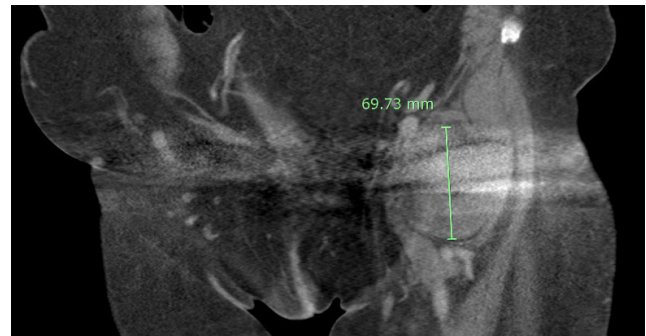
Coronal View, CT imaging of abdomen and pelvis with left pseudotumor measuring 6.9 cm in length.
